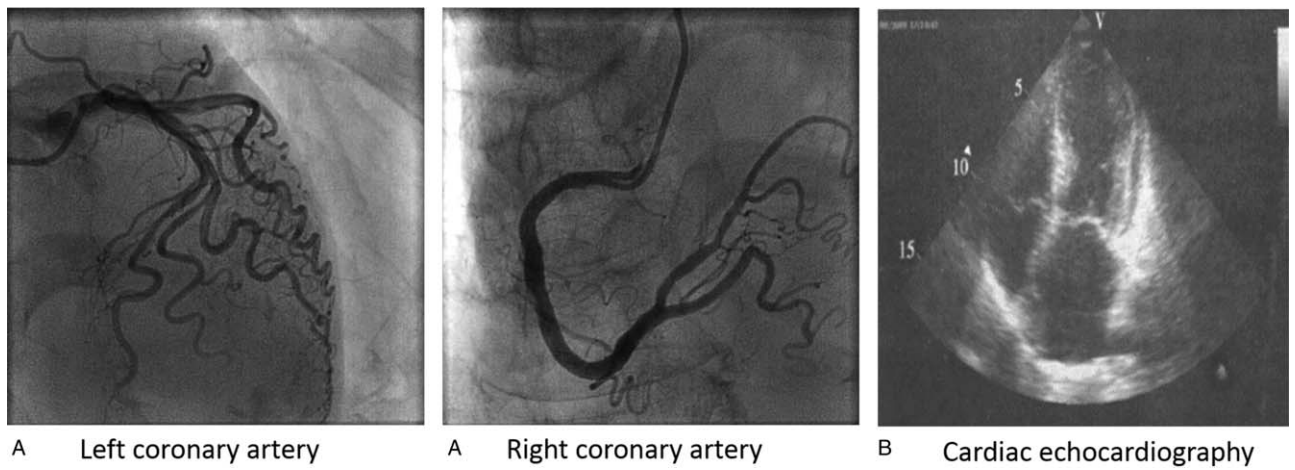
(A) Coronary angiography showing no obvious coronary artery stenosis. (B) Cardiac echocardiography showing hypokinetic apical mid-segments and hyperkinetic basal segments of the left ventricle.
